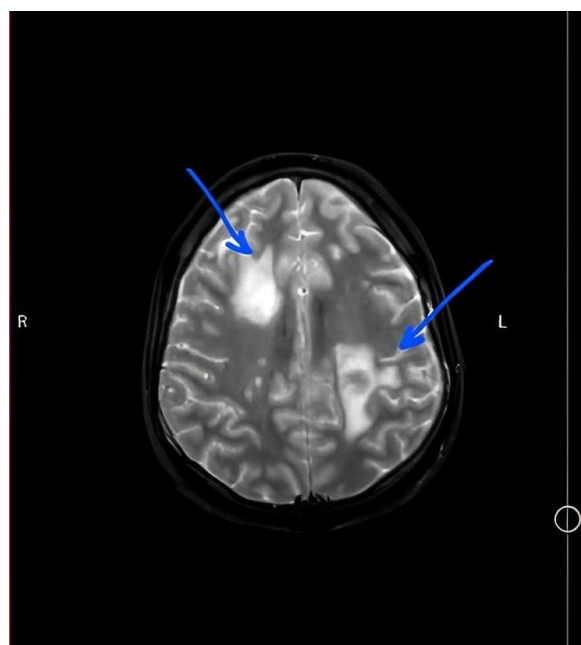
Brain CT scan of the patient. Marked areas show abscesses located in his brain.
